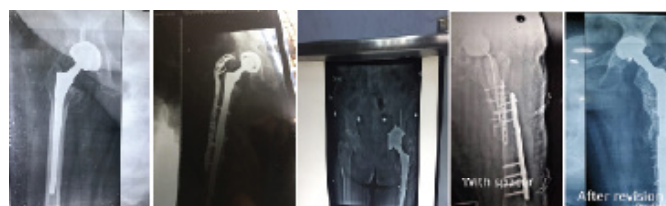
Post-operative radiograph antero-posteriore view of pelvis showing use of long stem cement less in the second stage and with treatment of fractures by different methods.
